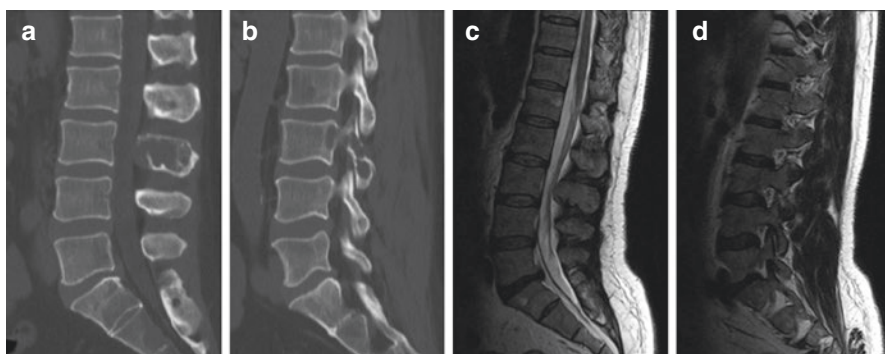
(a–d) Sagittal CT reconstructions in a patient with multiple myeloma revealing multiple lytic lesions, most pronounced in the posterior vertebral elements of L3 (a, b). Sagittal T1-WI MRI in the same patient shows multiple low intensity lesions (c, d)
